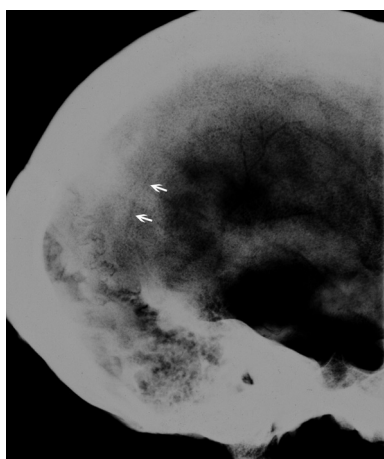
X-ray of the right posterior parietal with a delicate semicircular linear transparency (marked with white arrows) in front of the lambdoid suture.
